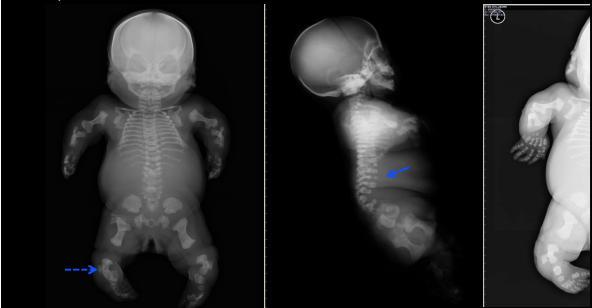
First sibling at 20 weeks gestation. A, Radiograph (AP view) demonstrates chondrodysplasia punctata with foci of multiple punctate epiphyseal calcifications, ectopic cartilaginous calcifications, severe asymmetric shortening and bowing of long bones, angulated fracture of the left tibia, profound platyspondyly, barrel shaped thorax and hypoplastic gracile ribs. B, AP photograph confirms radiographic findings, and demonstrates midface hypoplasia.
